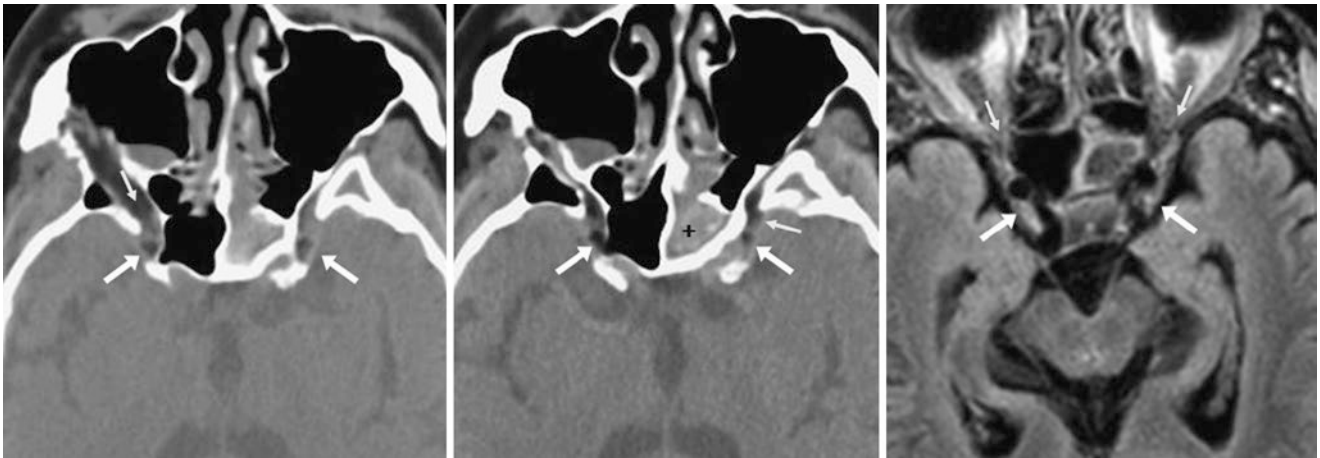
An 83-year-old female with facial trauma and normal bilateral cavernous sinus fat (*arrows*); note hemorrhage (+) within the sphenoid sinus. This fat is contiguous with the fat of the superior orbital fissures (*thin arrows*) as demonstrated on axial soft tissue windows (*left, middle*), and on 1.5 T FLAIR MRI (*right, no fat suppression*)
